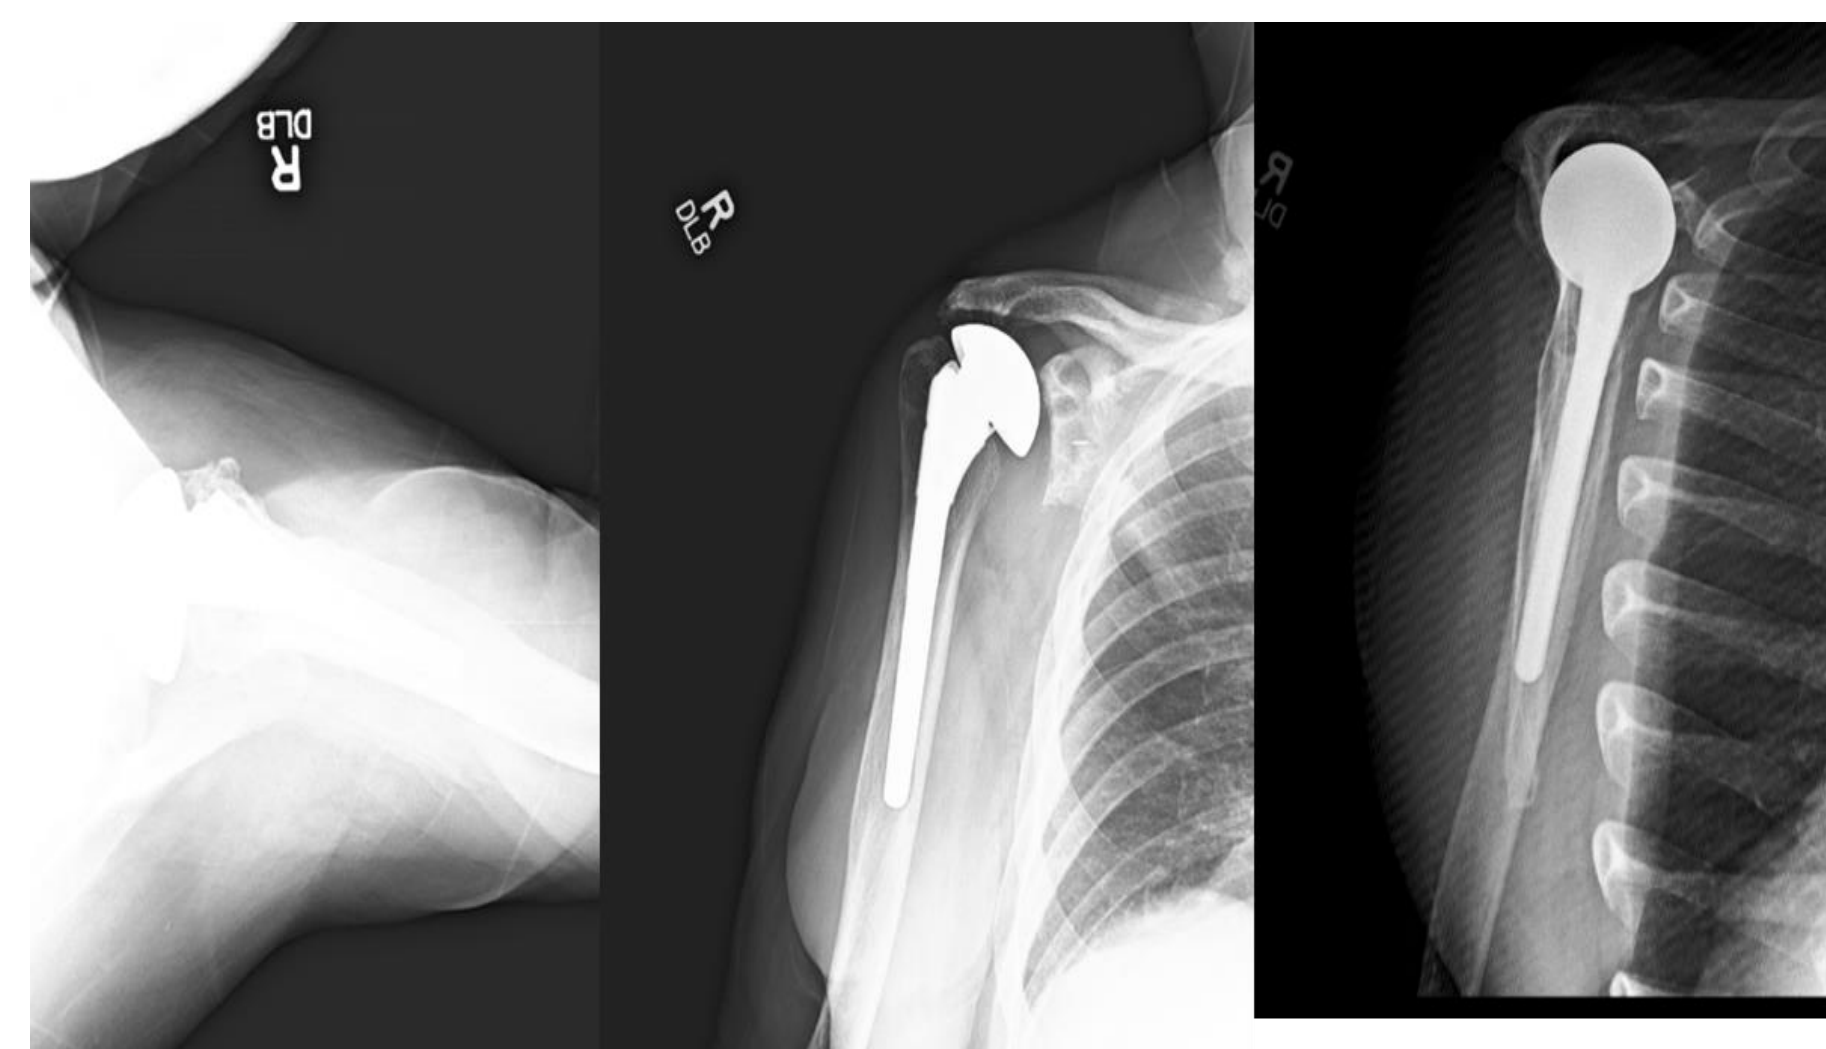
Radiographs revealing the original anatomic shoulder arthroplasty.
